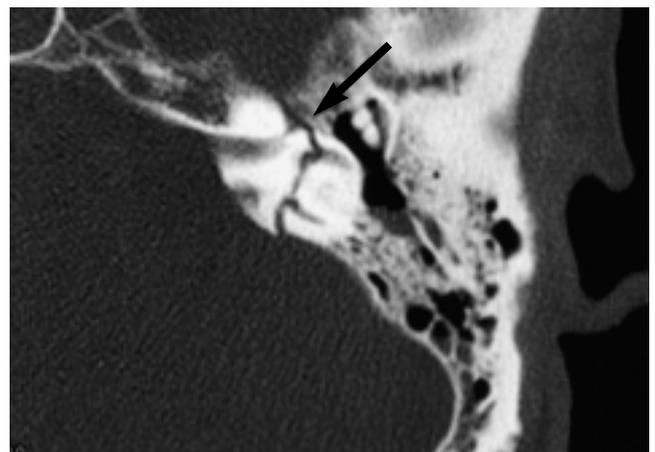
A 47-year-old man with grade IV facial nerve palsy and 100% degeneration on electroneuronography. Axial CT shows complex fracture involving ganglionic segment of the facial nerve canal and inner ear. The facial nerve canal is wide and reveals discontinuity and a bony fragment (arrow). This patient was operated and the bony fragment was removed. After surgery, symptom improved.
